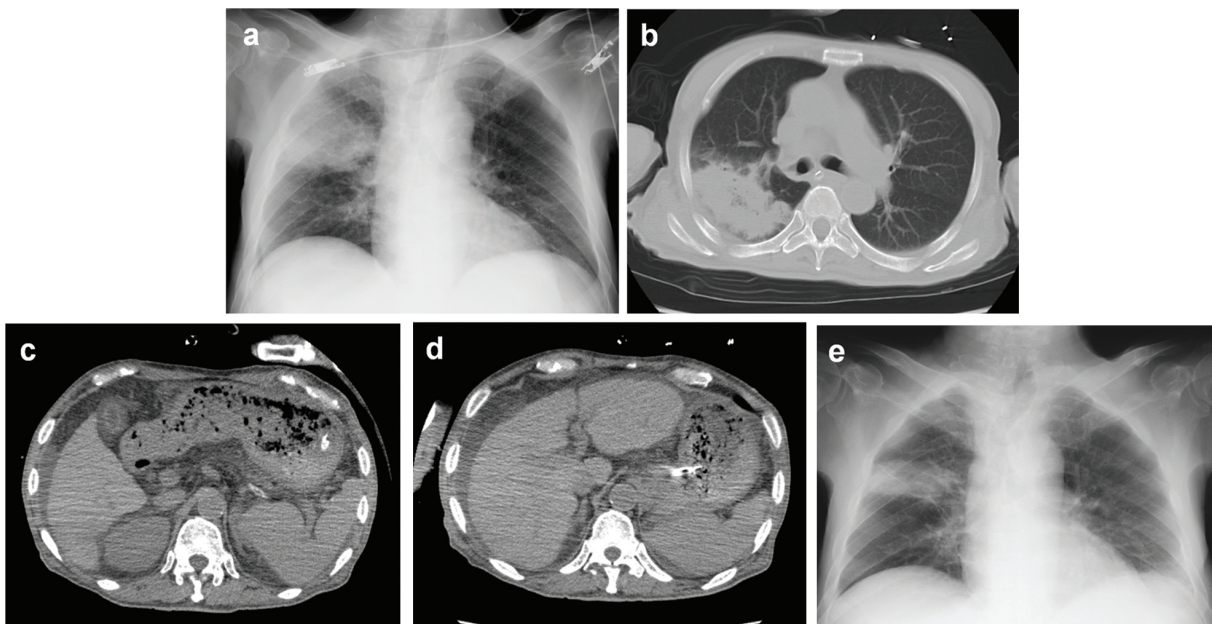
Radiological findings on admission. (a, b) Pneumonia in the right upper lobe was detected by X-ray and Computed tomography (CT); (c, d) CT of the abdomen showed atrophic liver and ascites, consistent with liver cirrhosis. Splenomegaly was not conspicuous; (e) A week after initiation of antibiotic therapy, pneumonia was well controlled
